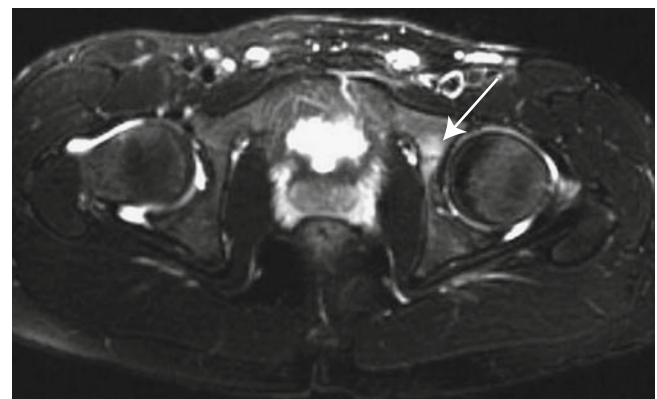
Axial MR image from a soccer player with persistent pain after an unsuccessful mesh hernia repair shows bone marrow edema and a dark, linear lesion at the triradiate cartilage physis (*arrow*) typical for a stress fracture
